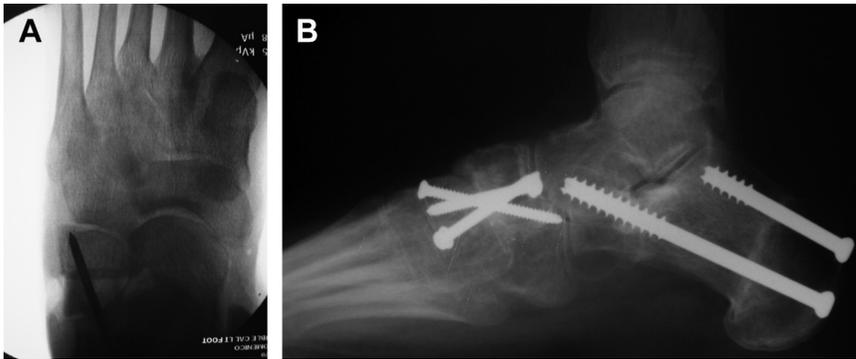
(A) An anterior to posterior guide wire inserted in preparation for a dual-function screw. Note the intramedullary fixation of the Evans calcaneal osteotomy. (B) Postoperative lateral radiograph showing the dual-function screw. This screw serves as a positional screw around the Evans osteotomy and an interfragmentary compression screw at the site of the percutaneous calcaneal osteotomy.
